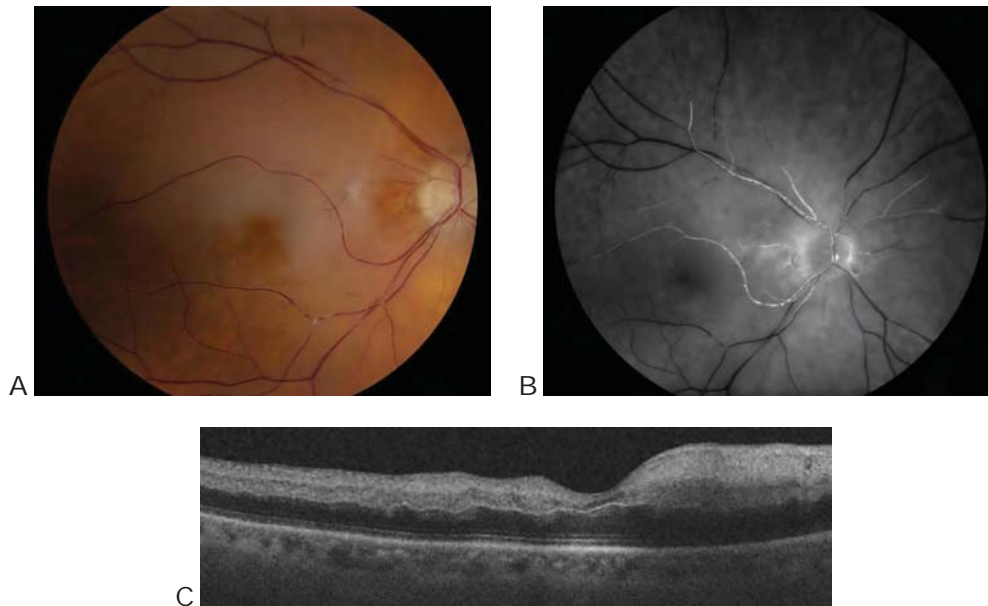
Central retinal artery occlusion (CRAO) caused by multiple emboli. A, The right eye shows diffuse retinal whitening, a cotton-wool spot, arteriolar attenuation, and multiple intraretinal refractile lesions in both superior and inferior arterial distributions. B, Fluorescein angiography shows markedly delayed arterial filling and “boxcarring” of blood flow within retinal arterioles. Subsequent computed tomography angiography revealed an ulcerative atherosclerotic plaque in the right internal carotid artery. C, Simultaneous OCT shows inner retinal hyperreflectivity due to retinal edema with corresponding hyporeflectivity of the outer retina. (Courtesy of Franco M. Recchia, MD.)
